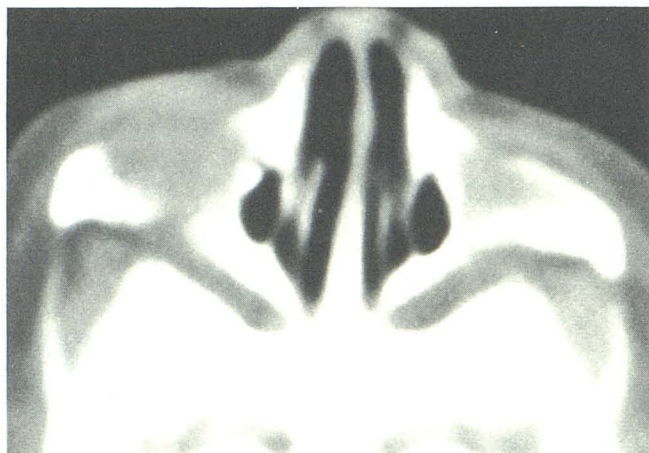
Normal maxillary sinus CT in a 3-week-old boy scanned because of facial hemangioma (not shown).
